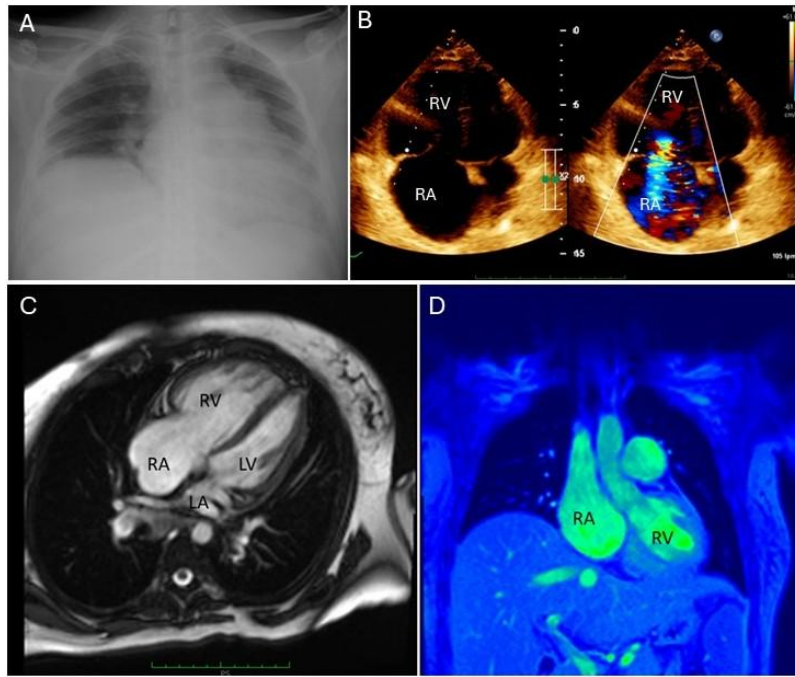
(A) Chest radiograph demonstrating cardiomegaly and bilateral pleural effusions. (B) Transthoracic echocardiography showing severe right atrial (RA) and right ventricular (RV) dilation with severe tricuspid regurgitation. (C-D) Cardiac magnetic resonance imaging confirming marked right-sided chamber enlargement on four-chamber (C) and coronal (D) views. LA: left atrium; LV: left ventricle
